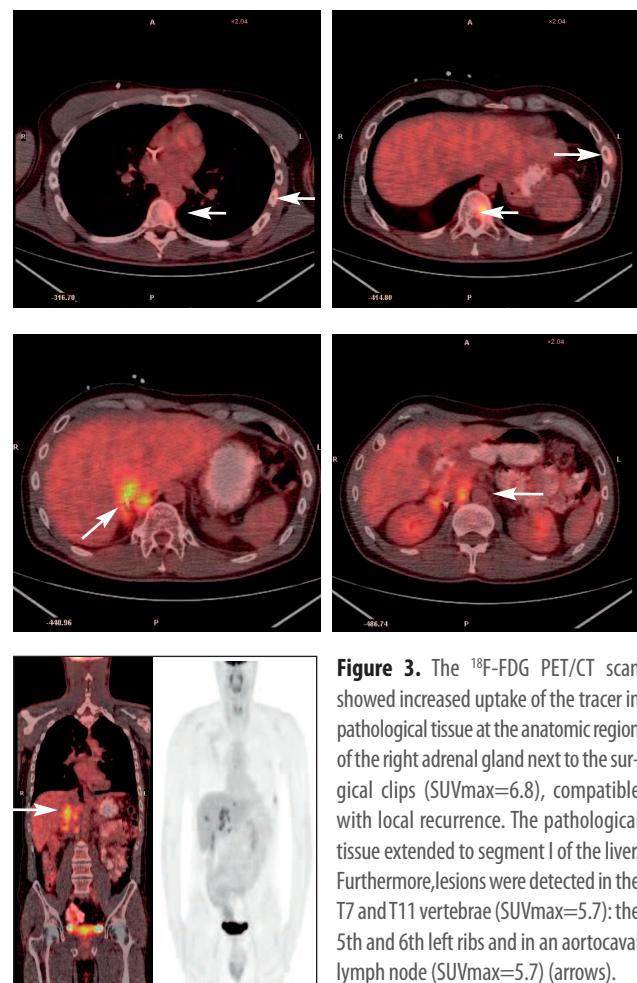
The ^{18}F -FDG PET/CT scan showed increased uptake of the tracer in pathological tissue at the anatomic region of the right adrenal gland next to the surgical clips ($\text{SUV}_{\max}=6.8$), compatible with local recurrence. The pathological tissue extended to segment I of the liver. Furthermore, lesions were detected in the T7 and T11 vertebrae ($\text{SUV}_{\max}=5.7$): the 5th and 6th left ribs and in an aortocaval lymph node ($\text{SUV}_{\max}=5.7$) (arrows).
